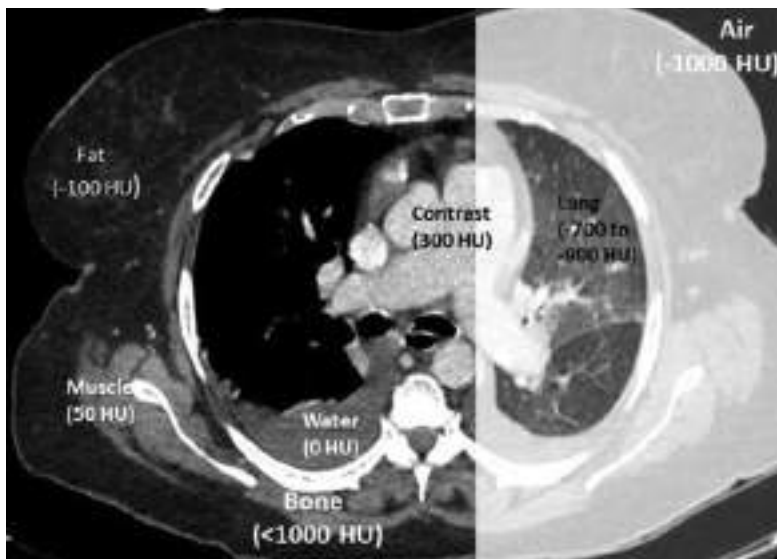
Typical Hounsfield unit values of anatomical structures in normal chest CT (left, mediastinal window; right, lung window). Note the right pleural effusion demonstrating water HU values.
